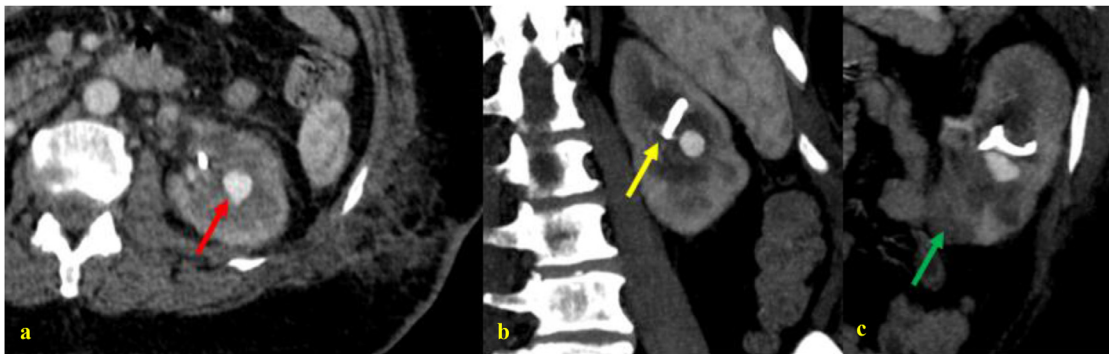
CT Urogram in arterial phase on axial (a), coronal (b) and sagittal (c) images demonstrating a medio renal aneurysm (red arrow) associated to a polar inferior infarct (green arrow) and a double J stent (yellow arrow).
